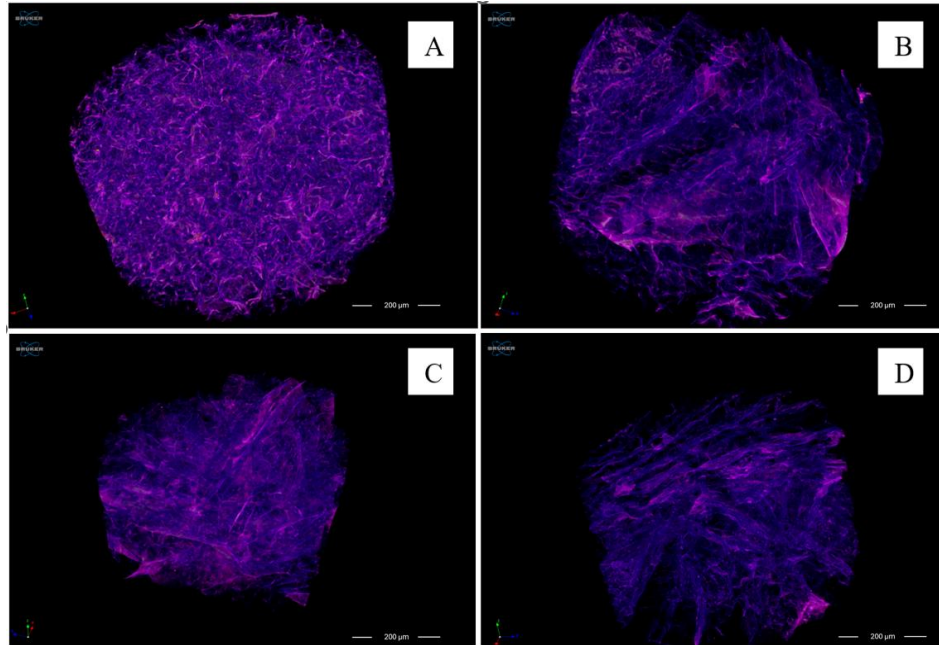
Micro CT Images of Control Sample (A), T 1% (B), T 3% (C), and T 5% (D).
